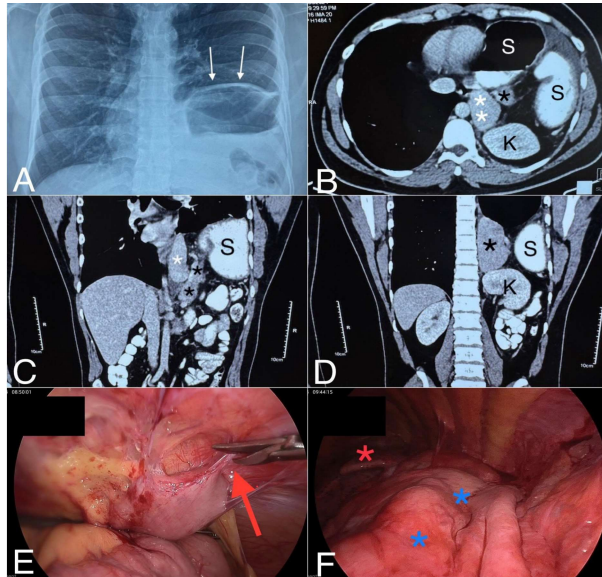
(A) Plain X-ray chest showing herniated contents thru left BH (white arrows), (B) CECT chest axial view herniated stomach ('S'), left kidney ('K'), spleen (white asterisks) & pancreas (black asterisk), (C) CECT oblique view herniated stomach, spleen (white asterisk) & pancreas (black asterisks), (D) CECT coronal view showing herniated stomach, kidney and spleen (black asterisk), (E) Operative pic showing lysis of small bowel adhesions to parietes (blue arrow), (F) shows view of left chest thru BH with large stretch of stomach (blue asterisks) & left lung (red asterisk)
